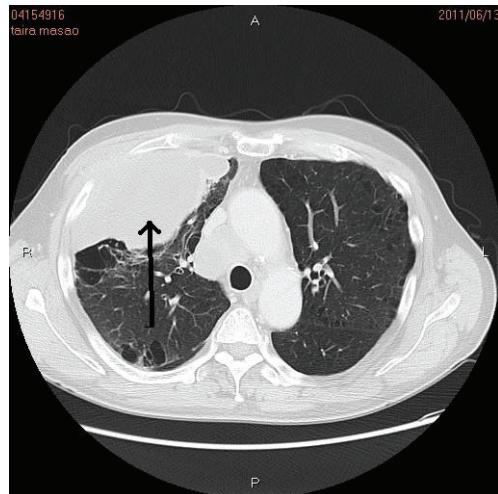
CT demonstrates a solid tumor (10 x 10 x 9cm) (arrow) in the right upper lobe.
